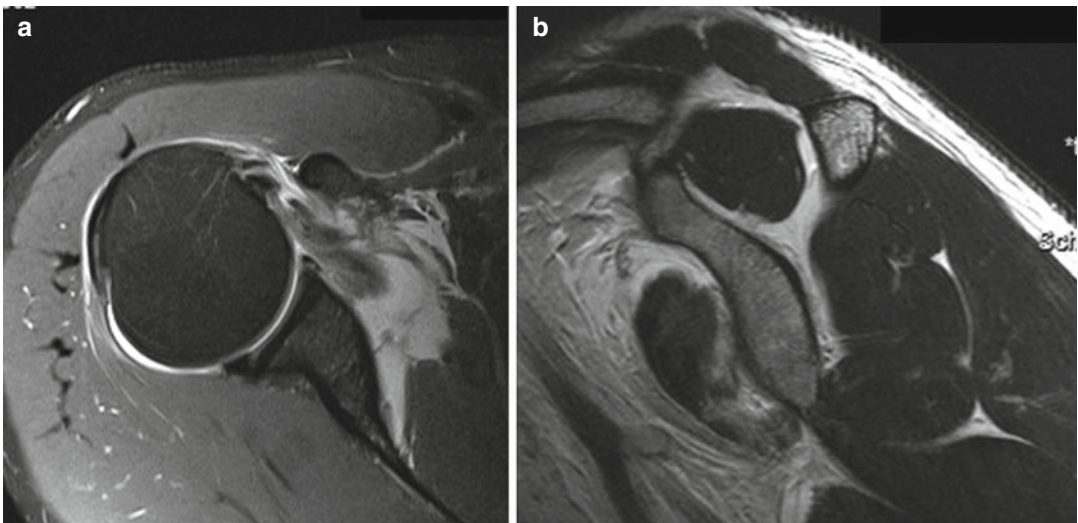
MRI scan SSC tear Fox/Romeo III: (a) axial view, (b) parasagittal view
